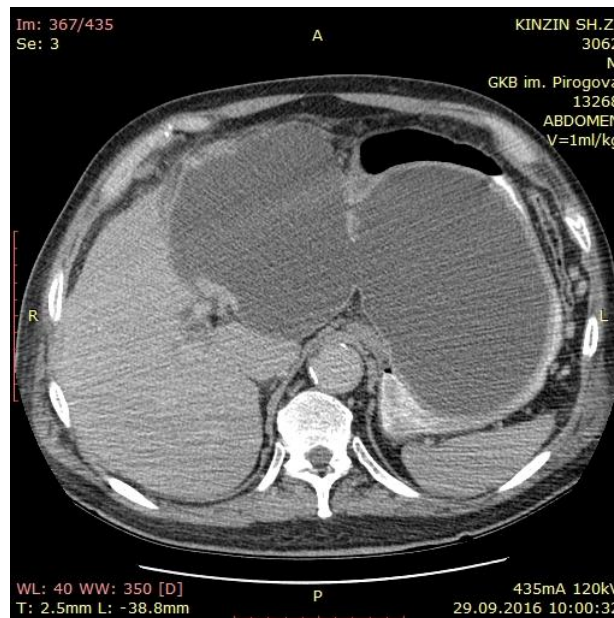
CT scan. Verification of the abscess cavity.
